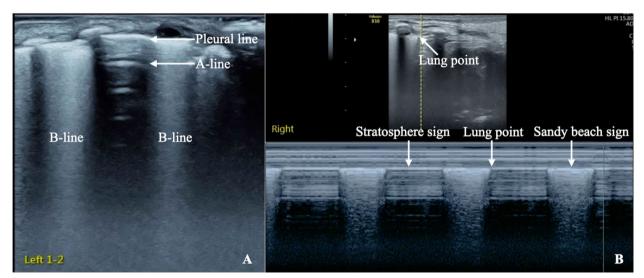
MV is generally unnecessary for mild pneumothorax. For pneumothorax patient, if spared area (the area that pleural line and A line clearly display surrounded by edema)(A) or lung point (B) exists in the LUS images. It could be mostly mild pneumothorax, usually no MV treatment needed, the real-time ultrasound examination clearly display the presence of lung point, which was a mild pneumothorax involves less than one intercostal space. Please also refer to Video 2
